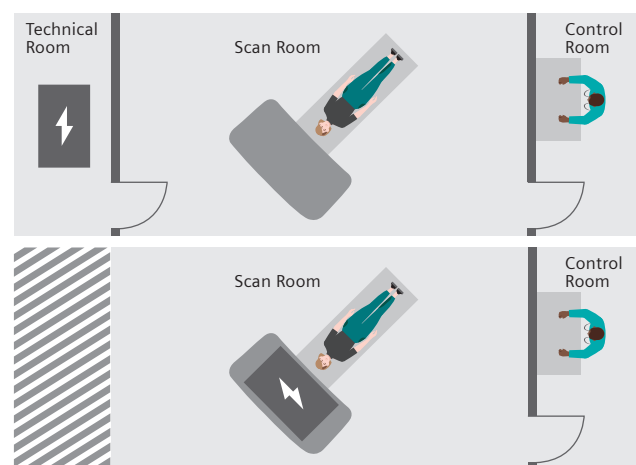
Most CT scanners require a separate technical room. This space is gained with the integrated power distribution units of SOMATOM Pro.Pulse.
